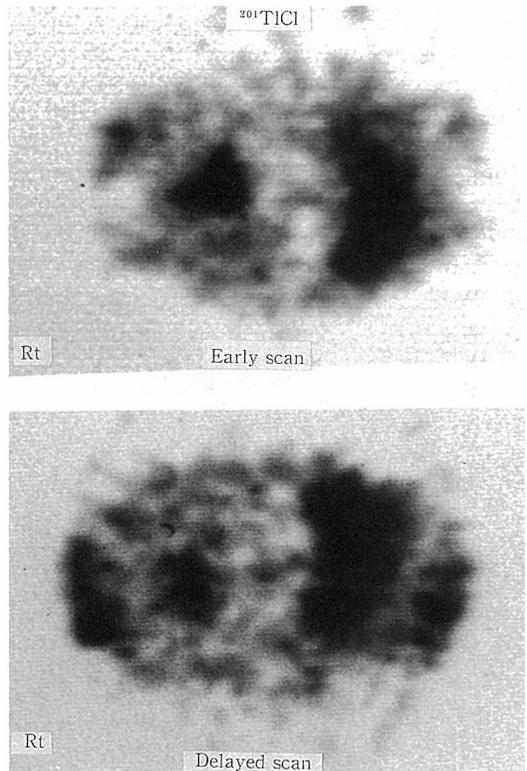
Early and delayed images of ²⁰¹TlCl SPECT showed abnormal uptake in the lesions. In the lesion of the left upper lobe, the early ratio, the delayed ratio and the retention index was 2.73, 4.00 and 46.5%, respectively. Those of the lesion of the right upper lobe were 1.15, 1.38 and 20.0%, respectively.
